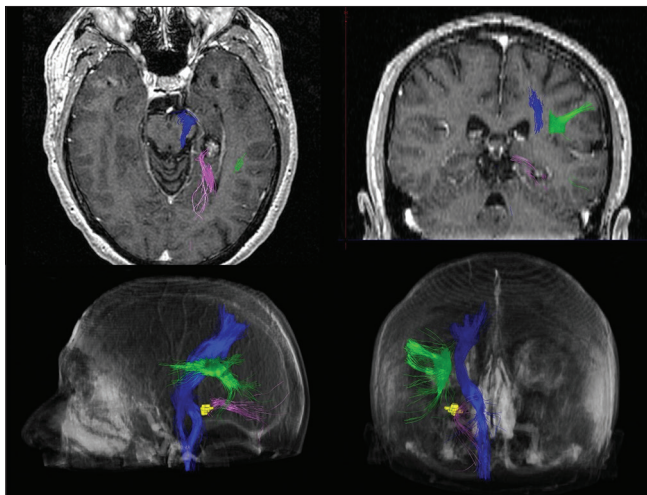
Preoperative magnetic resonance imaging with tractography. Lesion in the left temporal parahippocampal gyrus suggestive of cavernoma. Note the proximity of the visual or retinogeniculo-calcarine tract (pink color). The arcuate fascicle is shown in green and the corticospinal tract in blue.
